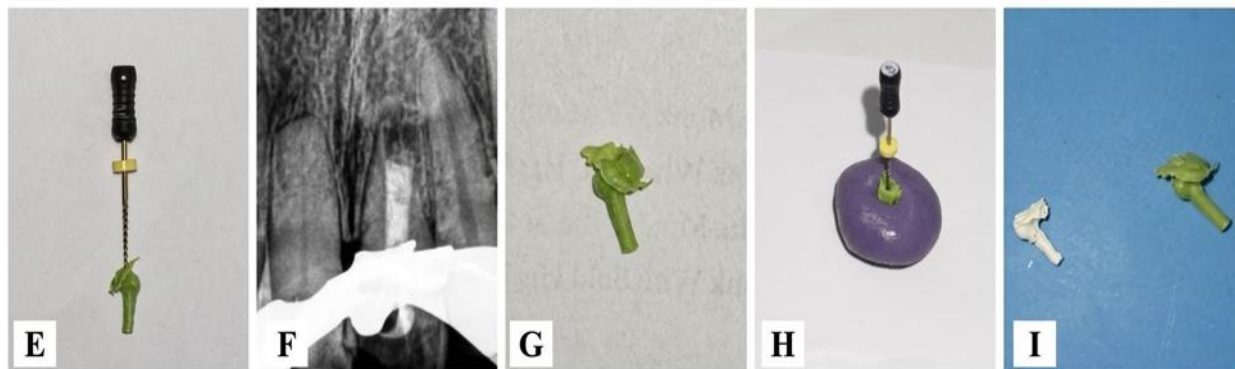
Fabrication of preset MTA plug. (E) Canal impression obtained using polyvinyl siloxane attached to an endodontic file. (F) Radiograph showing intracanal calcium hydroxide medicament placement. (G) Impression trimmed to a level 2 mm below the cemento-enamel junction. (H) Positive replica prepared using putty support. (I) Preset mineral trioxide aggregate plug after setting alongside the original impression mold
